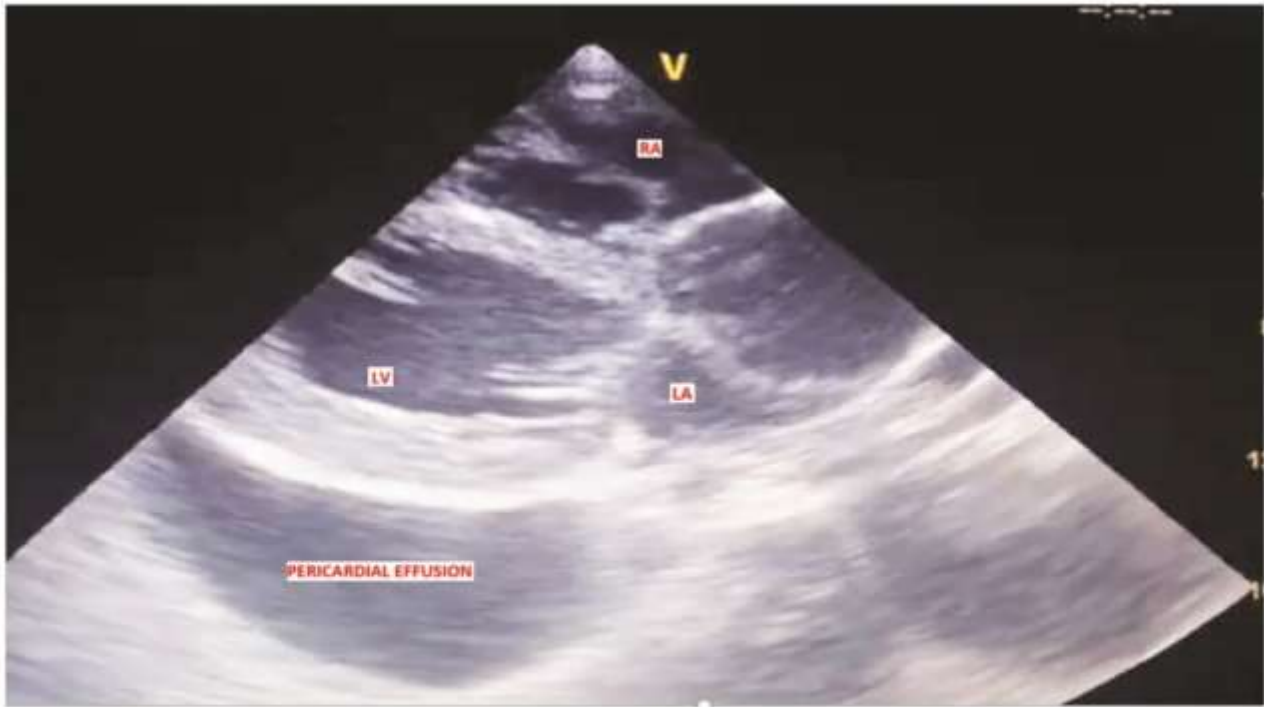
Patient's Echocardiography
